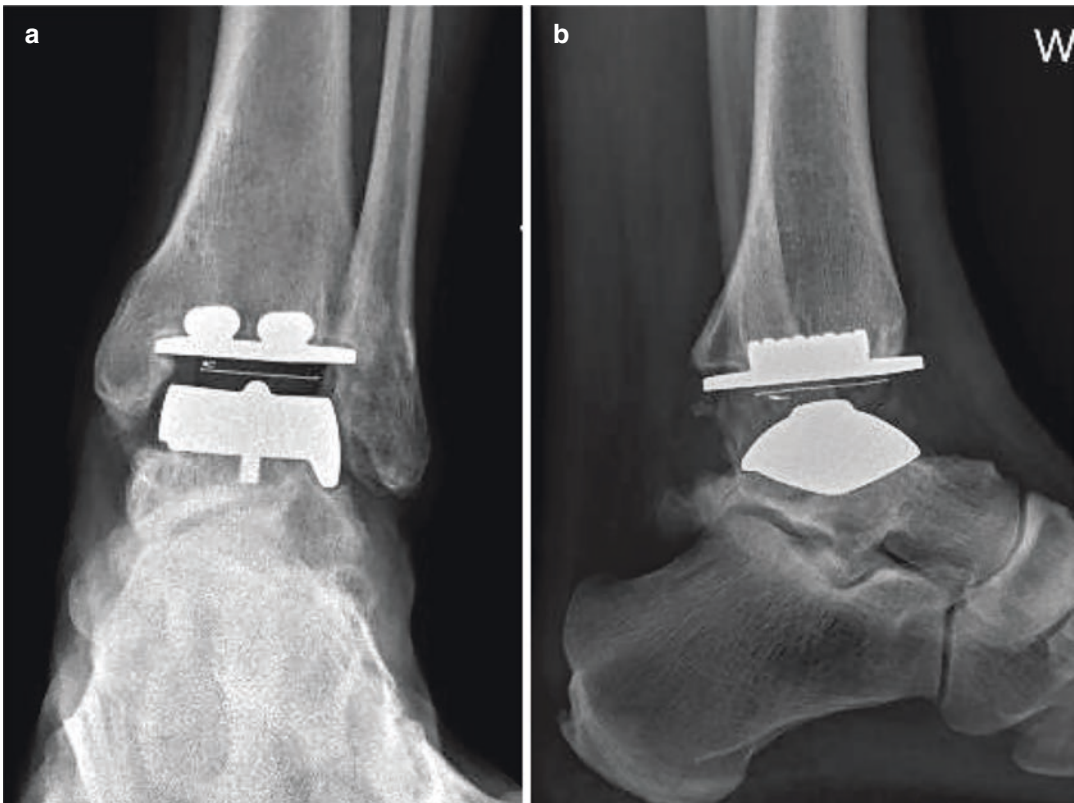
SPECT imaging is valuable for diagnosing the source of pain in total ankle arthroplasty. (a, b) Radiographs suggest a potential lucency under the talar
